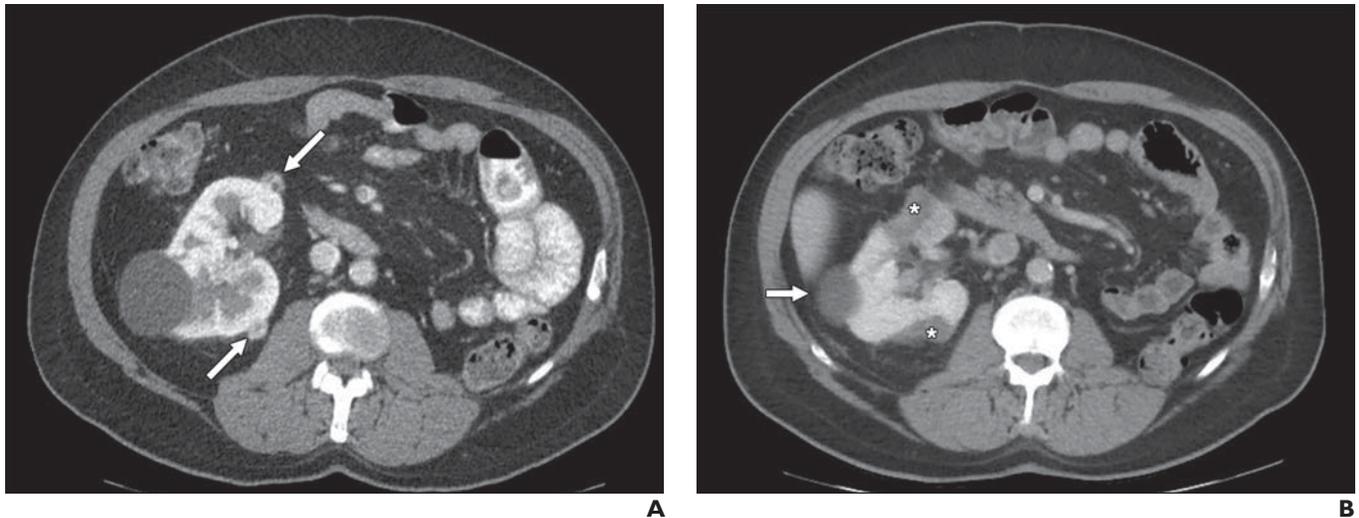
67-year-old man with history of left nephrectomy for renal cell carcinoma (RCC) who presented with multifocal RCC in right kidney. A, Axial contrast-enhanced CT scan of abdomen shows multiple right RCCs (arrows). B, Axial contrast-enhanced CT scan of abdomen obtained 1 month after microwave ablation of multifocal right RCC. Asterisks indicate zones of ablation. Arrow indicates benign cyst.
